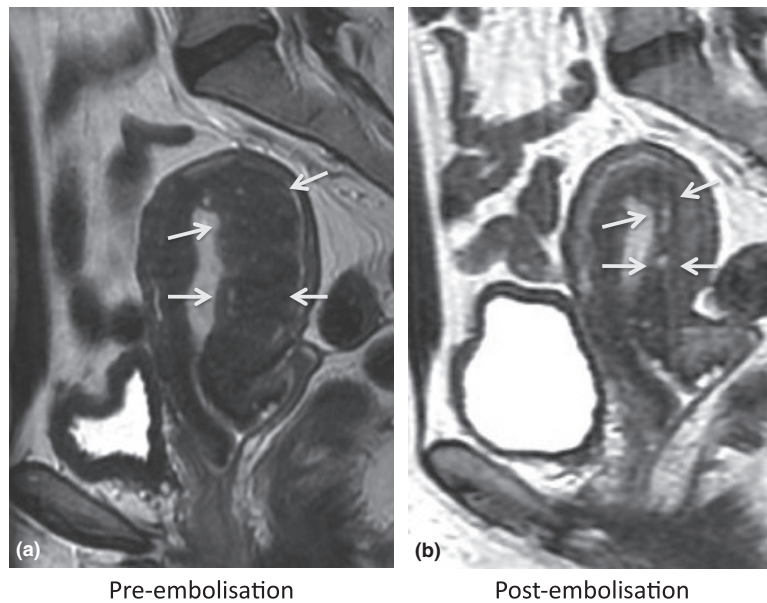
A case of disappearing large fibroid. 48 yr G0P0 presented with severe menorrhagia and anaemia (Hb 6.3 g/dL), urinary and bulk symptoms. There was a 500-mL fibroid (arrows) on the pre-UFE MRI (a, b) and disappearance of this large fibroid on the six-month post-UFE MRI (c, d). There was also significant reduction in overall uterine volume reduction from 1300 to 129 mL. At six-month follow-up, she had complete resolution of menorrhagia and bulk-related symptoms. This was sustained at 18-month follow-up. The woman had a three-day admission to another institution at two months post-UFE, for pain, fever and vaginal discharge. She was managed conservatively with IV antibiotics and analgesia, with presumed diagnosis of endometritis. She denies passage of any noticeable fibroid masses.
